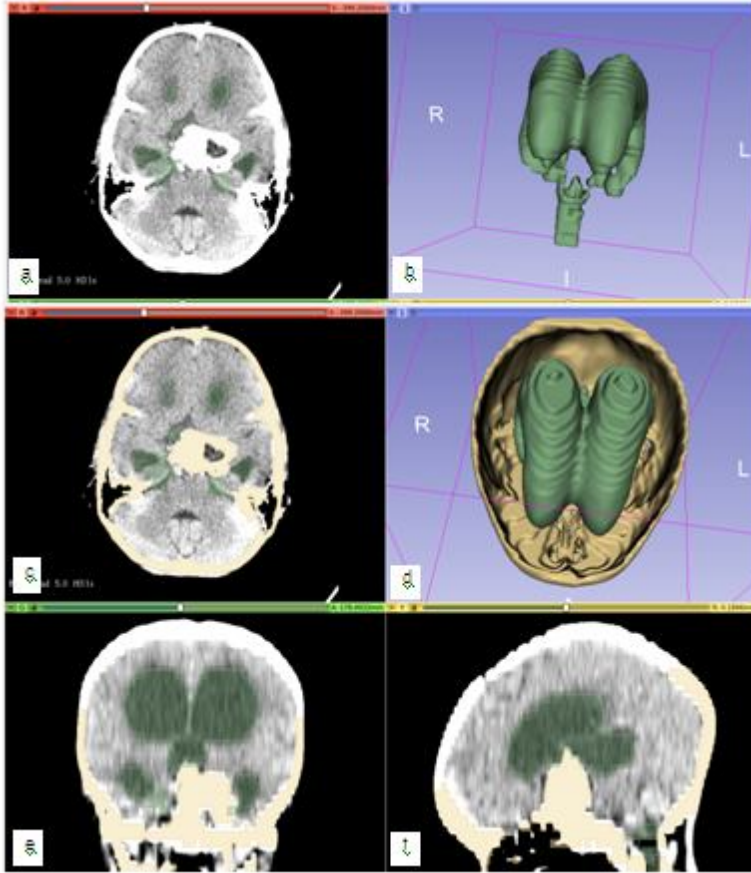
Case 2 a-f: Lobulated predominantly calcified mass in pituitary fossa. Axial, coronal, and sagittal CT Images showing dilated ventricles and calcified sellar mass (a, c, e & f). Segmented stacks with 3D volume rendered images of the dilated ventricles and skull (b & d).
